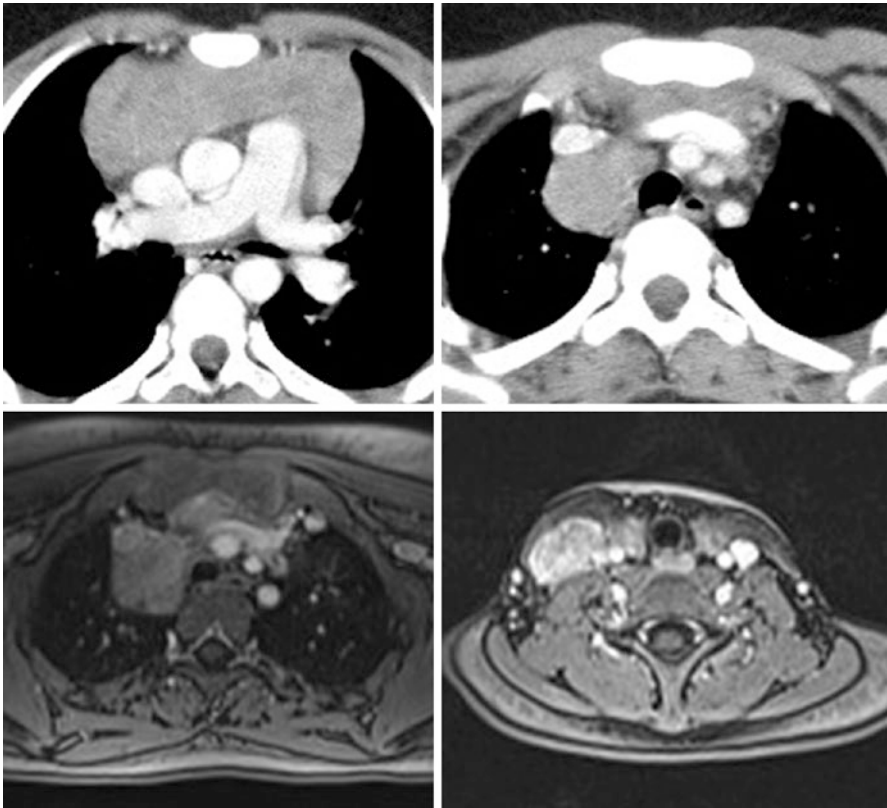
Chest and neck CT/MRI with contrast. Recurrence of mediastinal lymphoma with involvement of the supraclavicular region
